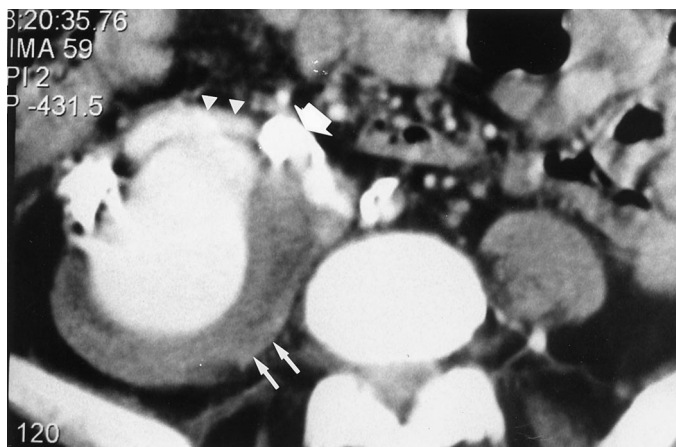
Contrast-enhanced CT scan of the pelvis shows a 7-cm pseudoaneurysm with enhancement of its lumen and nonenhancing wall of 1.5-cm thickness (*arrows*). The neck of the pseudoaneurysm (*arrowheads*) arises from the right common iliac artery (*large arrow*).
